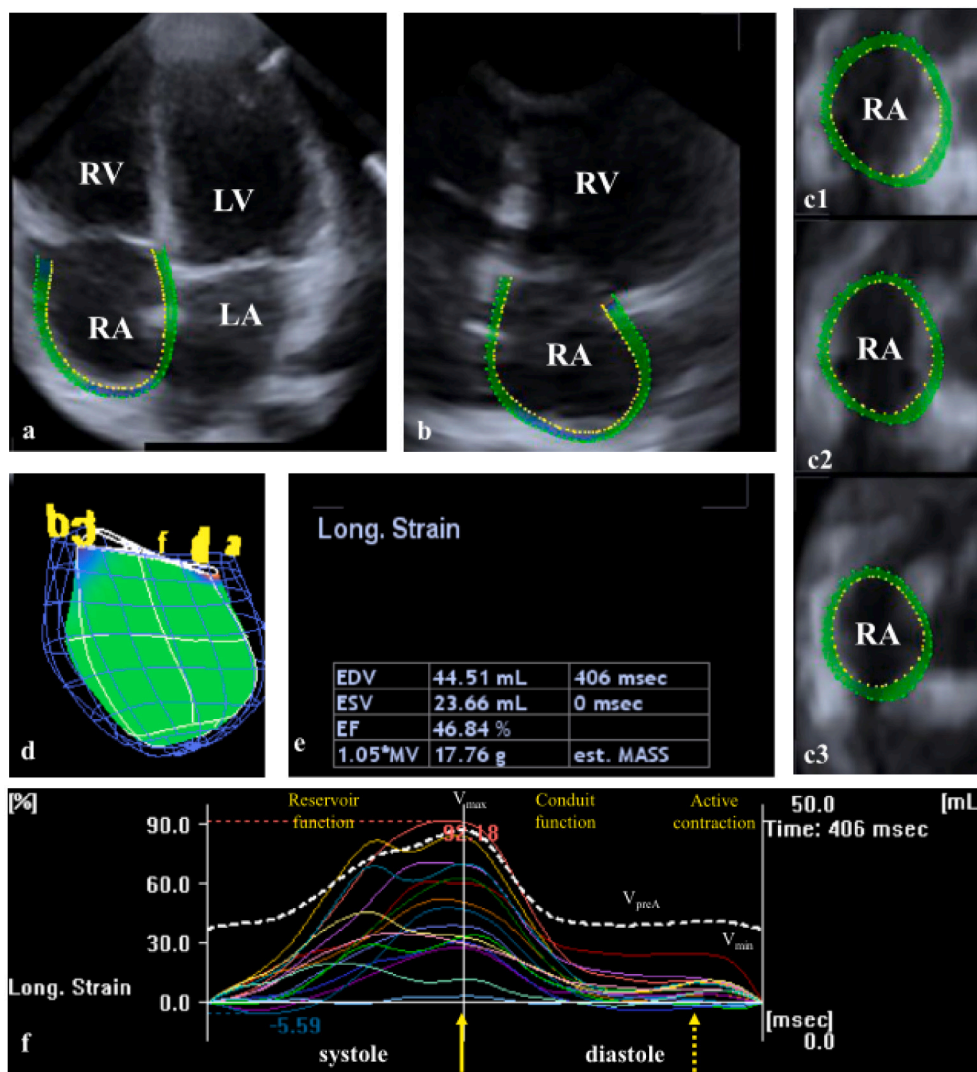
Images from three-dimensional (3D) full-volume dataset showing the right atrium (RA) in a healthy subject [61] are demonstrated (a, b): a apical four-chamber view, b apical two-chamber view, c1 parasternal short-axis view at basal, c2 mid- and c3 superior RA levels. In d 3D reconstruction of the RA based on 3D speckle tracking echocardiographic analysis is presented. In e RA volumetric data are demonstrated. Colored lines represent segmental RA strains while dashed white line represents RA volume changes over the cardiac cycle (f). Yellow arrow represents peak RA strain, while dashed arrow represents RA strain at atrial contraction.
